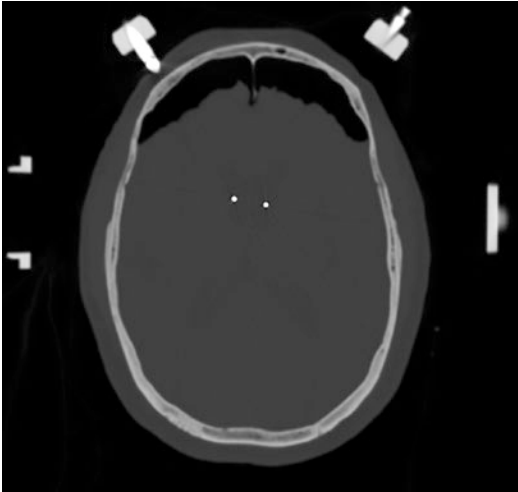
Intraoperative computed tomography showing extensive pneumocephalus following bilateral deep brain stimulation lead placement. The arc supports are seen laterally and the pins are seen anteriorly. (Used with permission from Barrow Neurological Institute, Phoenix, Arizona)
